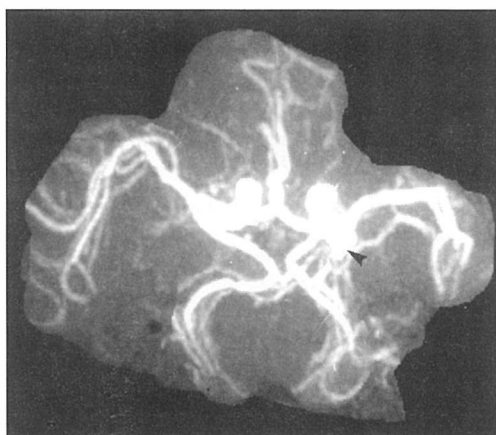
Inferior view CT angiogram (maximum intensity projection) demonstrates left posterior communicating artery aneurysm and calcifications within the neck of this aneurysm (arrow).
